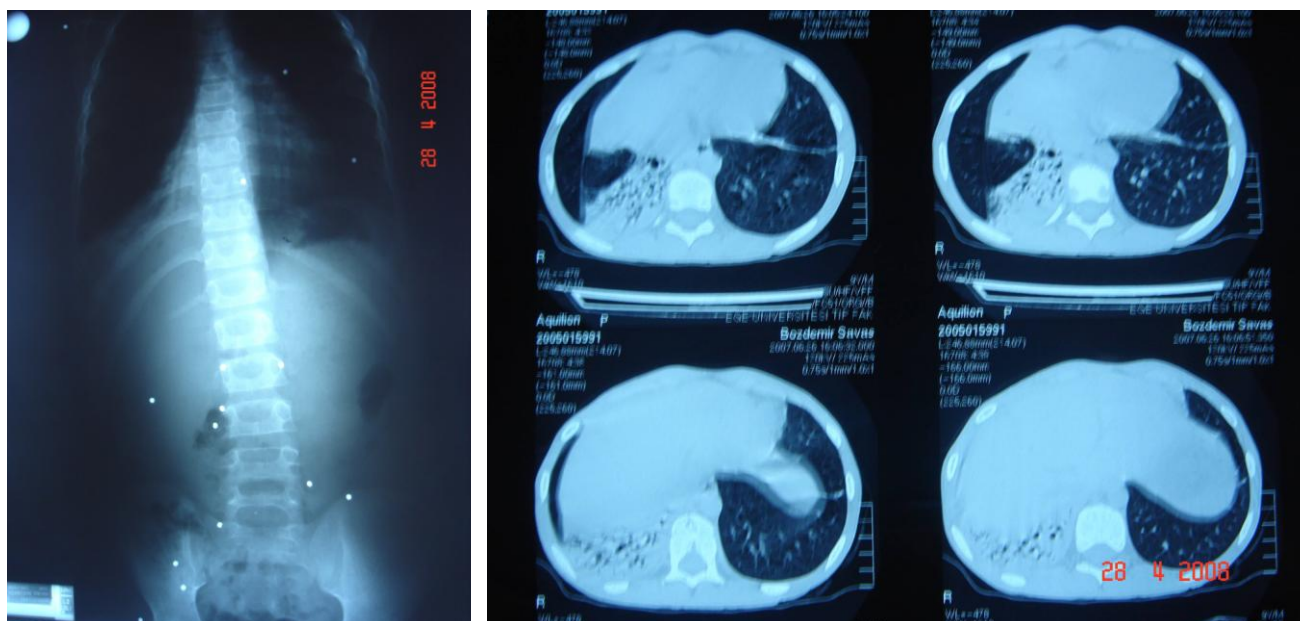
Plain abdominal radiography and thoracic tomography of the patient subjected to pellet wound.
